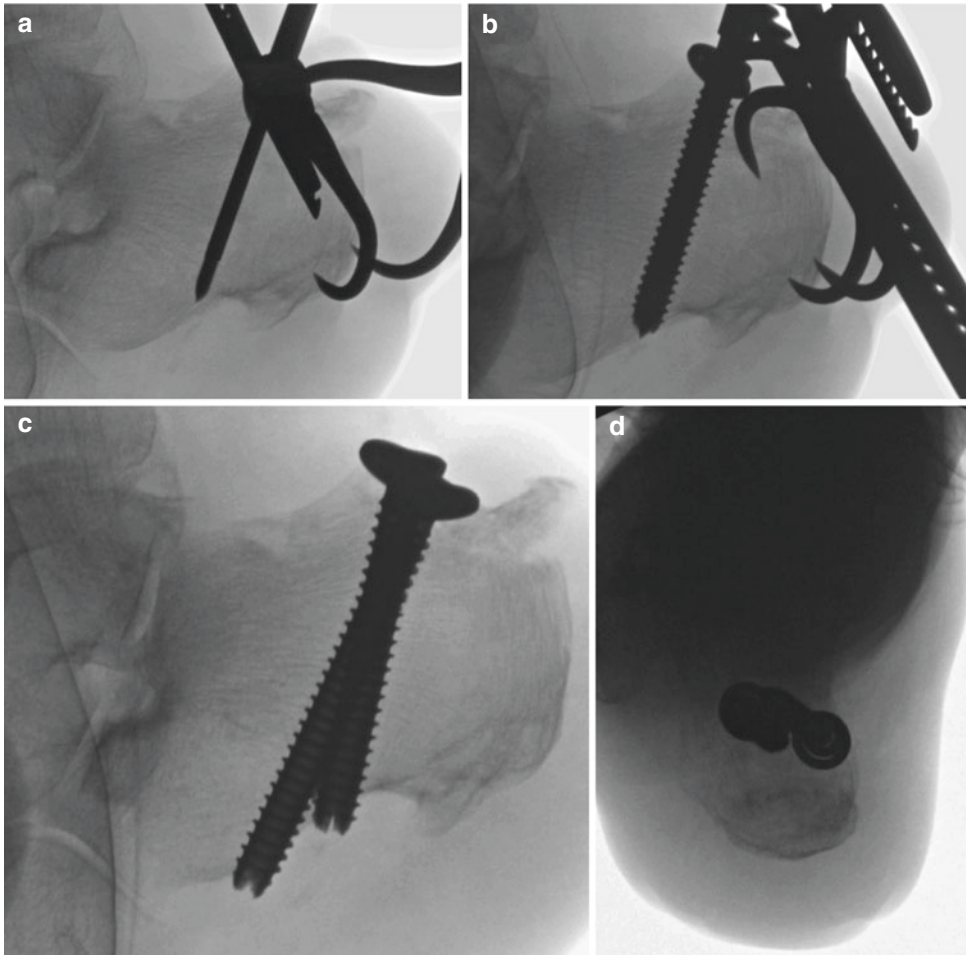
Lateral radiographs demonstrating (a) guidewire placement and (b) screw placement. Final fluoroscopic (c) lateral and (d) Harris views
